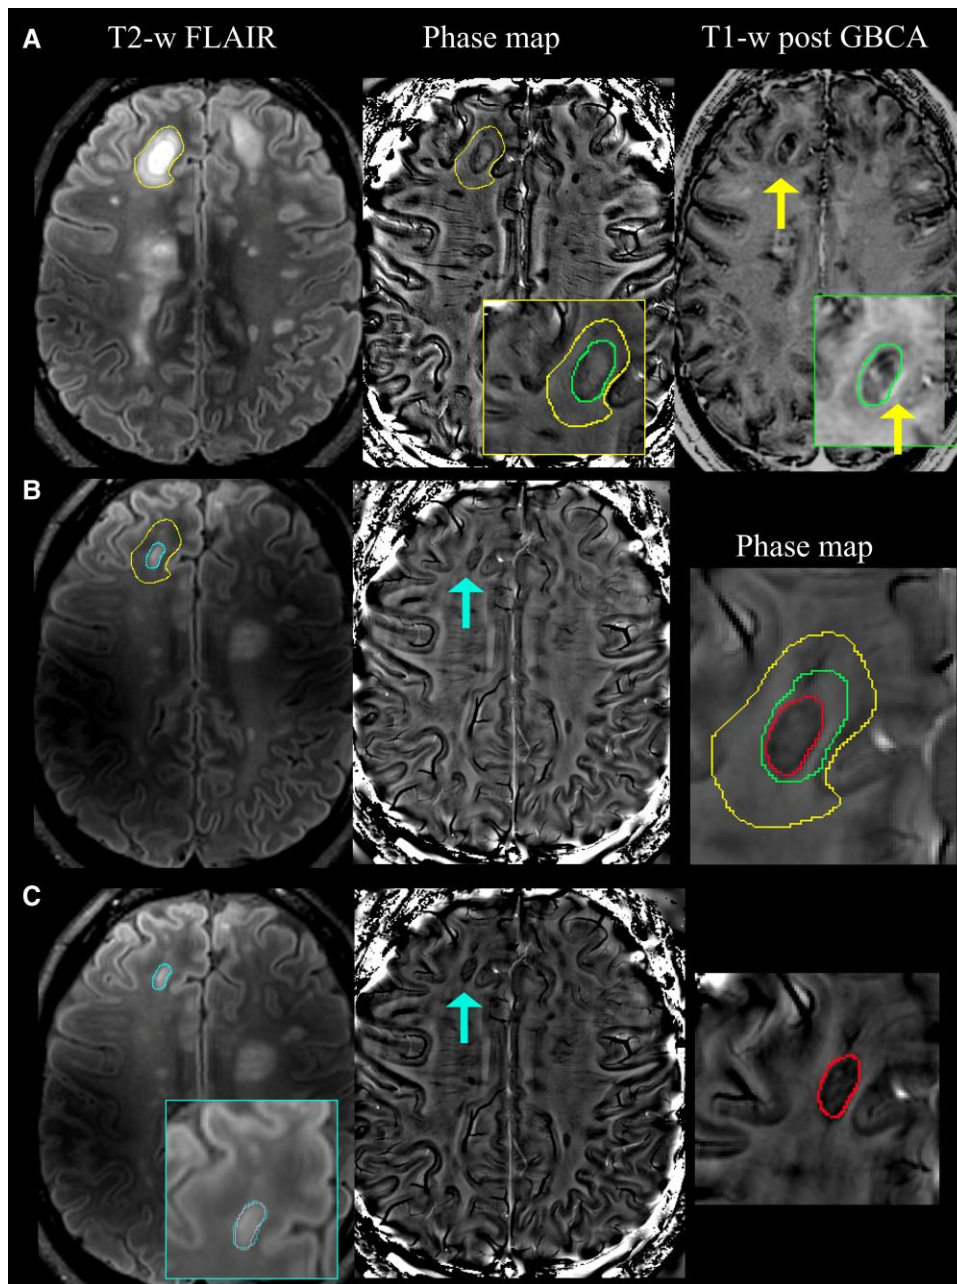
Paramagnetic rim lesion persisting upon resolution of gadolinium-based contrast enhancement. (A) T₂-weighted fluid attenuated inversion recovery (T₂-w FLAIR) image at 7 T showing a hyperintense lesion delineated by the yellow contour. The central more hyperintense core of the lesion is surrounded by a paramagnetic rim, as seen on the phase map presented next. There is likely vasogenic oedema (T₂-hyperintense signal) peripheral to the paramagnetic rim (green contour). The lesion also has gadolinium enhancement [yellow arrows on the T₁-weighted post-gadolinium-based contrast agent (GBCA) MRI], which co-localizes with the rim. Co-localization is shown with a green contour in the insets of the phase and T₁-weighted post-GBCA MRI. Note that on this scan, the lesion cannot be called a paramagnetic rim lesion (PRL) because it demonstrates contrast enhancement. (B) A year later, there is partial resolution of the previous large lesion on T₂-weighted FLAIR, now limited to the core area contoured in light blue (larger magnification in the *middle inset*). The lesion is no longer contrast-enhancing (data not shown) but retains PRL visibility on the phase map (indicated by the light blue arrow). The contour of the new phase rim is delineated in red, and it is contrasted with the size of the rim measured at baseline (green) and the overall lesion size at baseline (yellow). At this time point, the lesion can be called a PRL because it is no longer GBCA-enhancing and the paramagnetic rim (light blue arrow on phase map) co-localizes with the perimeter of the chronic lesion core (light blue) on T₂-weighted FLAIR. (C) At Year 2, the lesion has remained approximately of the same size as delineated by the purple contour (which nearly overlaps with the light blue one, refer to the T₂-weighted FLAIR *inset*). The PRL (light blue arrow on phase map) is also the same size (the red contour from Year 1 scan entirely overlaps with the rim on Year 2 scan, *inset*). Images were acquired on a person with newly diagnosed multiple sclerosis who was treatment naive at the time of the baseline scan. Image contributed by Dr Francesca Bagnato, Habeeb F. Kazimuddin and Jiacheng Wang.
